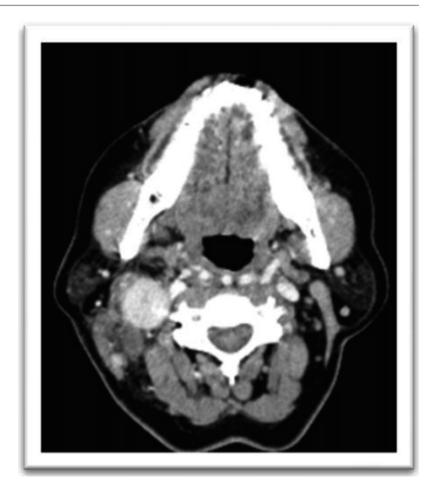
CT neck showing enlarged right upper deep cervical LN (level II)
